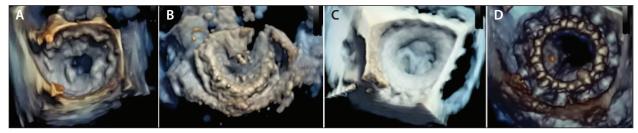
Postoperative 3D echocardiography ("surgeons view") after TMVI using Tendyne (A), Tiara (B), Highlife (C), and CardiAQ (D) bioprostheses.
